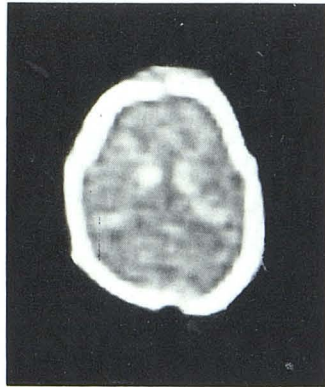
Subarachnoid, intracerebral, and intraventricular hemorrhage, hemorrhagic infarction, premature neonate, 36 weeks, birth weight 1,700 g. Death at 8th day from hyaline membrane disease and pneumonia. CT: subarachnoid, para-, and intraventricular hemorrhage. In left temporooccipital region, large intracerebral hemorrhage with central hypodense area (arrow). Autopsy: subependymal and intraventricular hemorrhage, secondary subarachnoid bleed. Left temporooccipital hemorrhagic infarction communicating with occipital horn.
